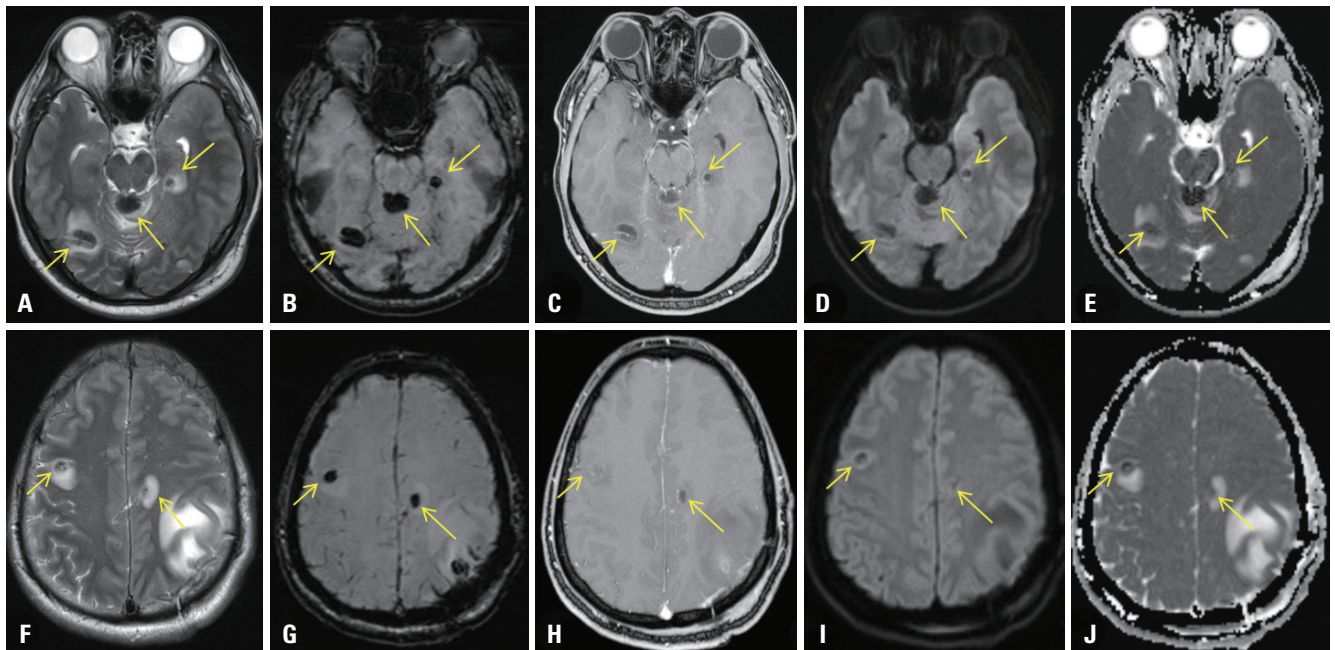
Follow-up MR. A week after biopsy, follow-up MR shows newly developed multifocal lesions. (A and F) T2-weighted axial MR images show multifocal dark signal intensity lesions (arrows) with surrounding edema at the superior cerebellar vermis, left inferior basal ganglia, right occipital white matter (A), and both frontal cortex and white matter areas (F). (B and G) Susceptibility weighted imaging shows intralesional dark signal intensity of the lesions (arrows) at the superior cerebellar vermis, left inferior basal ganglia, right occipital white matter (B), and both the frontal cortex and white matter area (G). (C and H) Gadolinium-enhanced T1-weighted images show marginal, thin rim enhancement of the lesion (arrows). (D, E, I, and J) Diffusion weighted image (D and I) and apparent diffusion coefficient maps (E and J) show central low signal intensity with surrounding edema of the lesions (arrows). MR, magnetic resonance.
